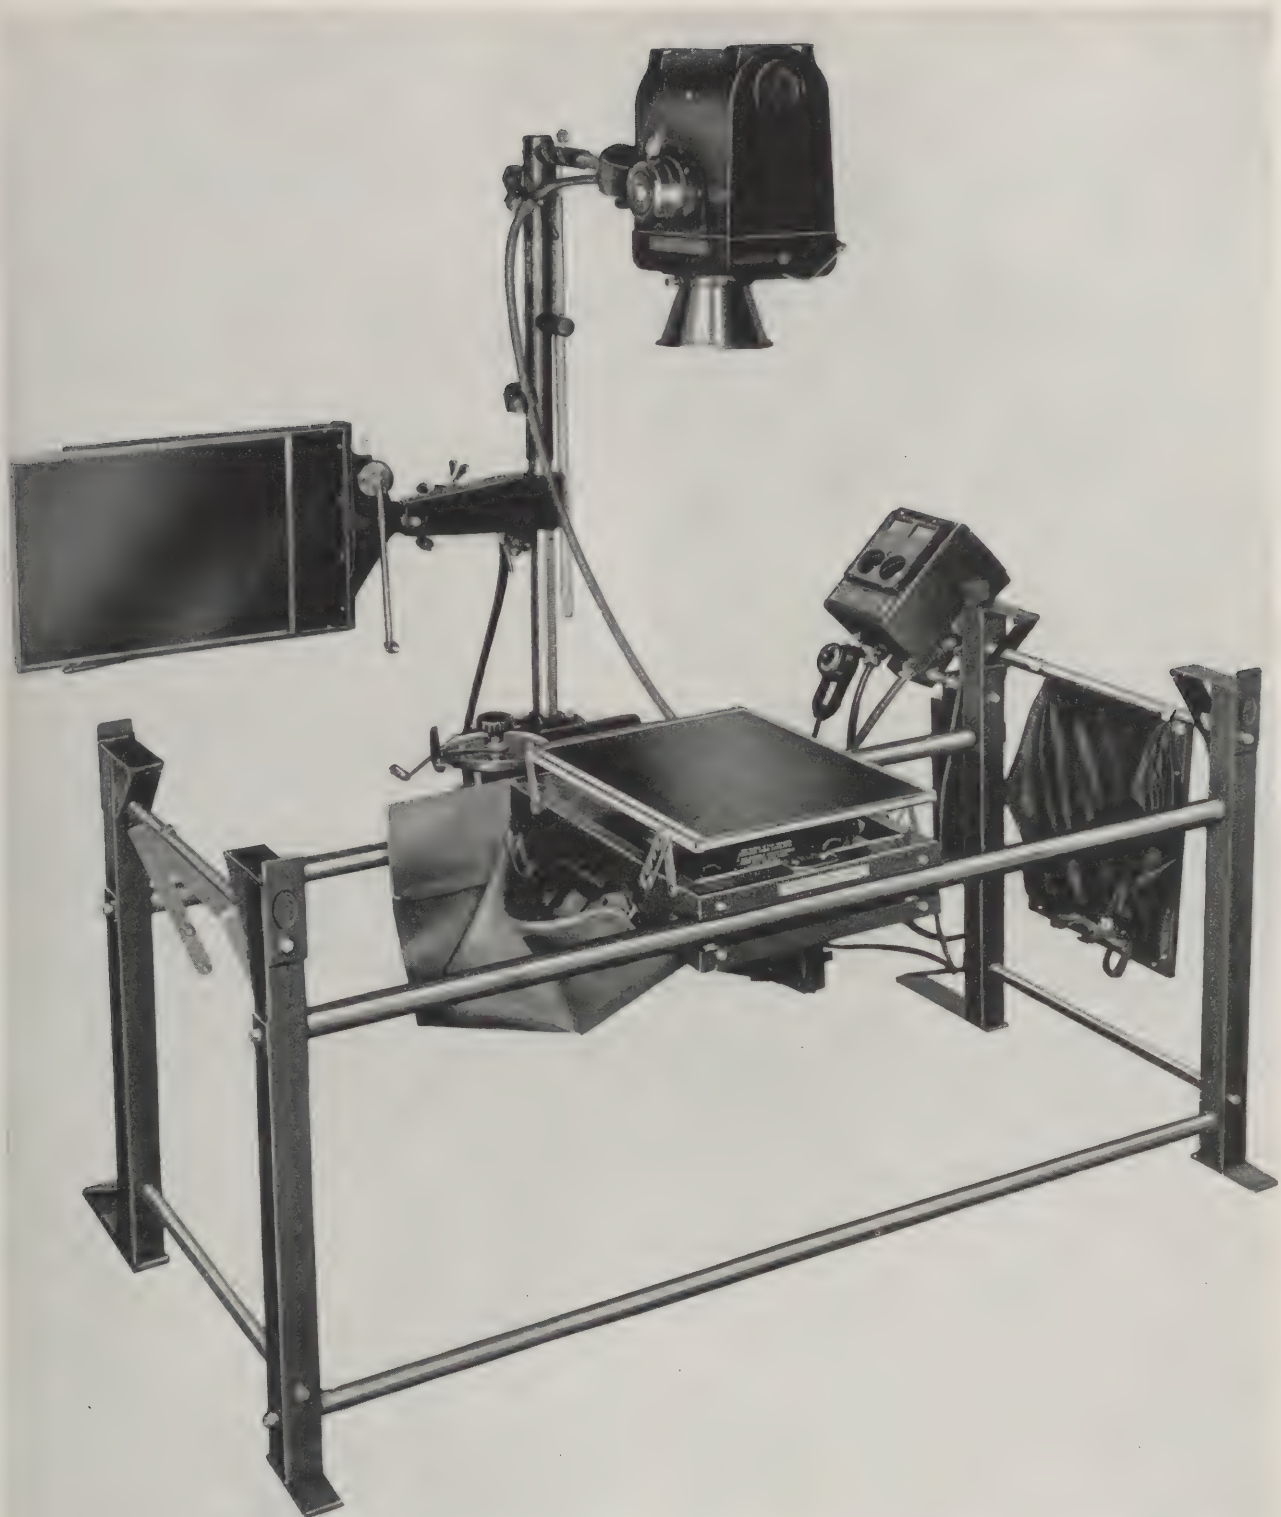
Item 96215 assembled for horizontal roentgenography.
